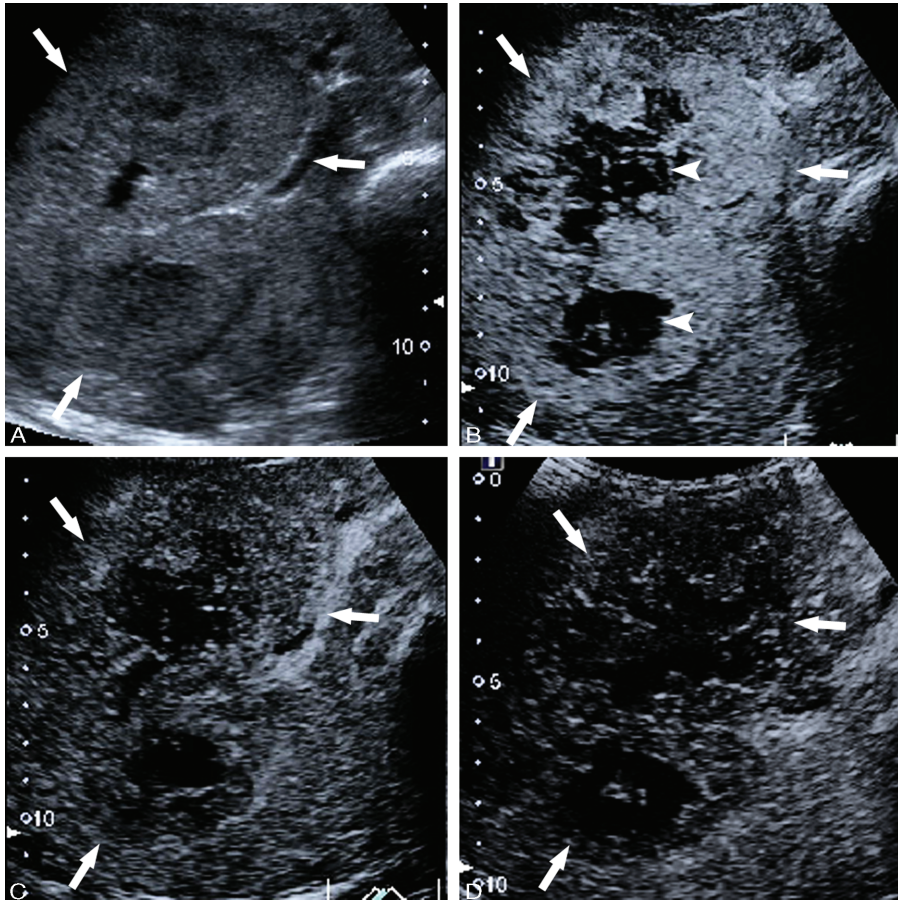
Primary hepatic neuroendocrine tumor in a 67-year-old woman (case 4). A, Conventional B-mode ultrasonography revealed a mixed solid cystic lesion (arrow) 12.7 cm in diameter. B–D, Contrast-enhanced ultrasonography obtained at 21 s (B), 73 s (C), and 140 s (D) showed heterogeneous hyperenhancement with a nonenhancement area (arrow head) in the arterial phase (B) and hypoenhancement in the portal venous and late phases.
